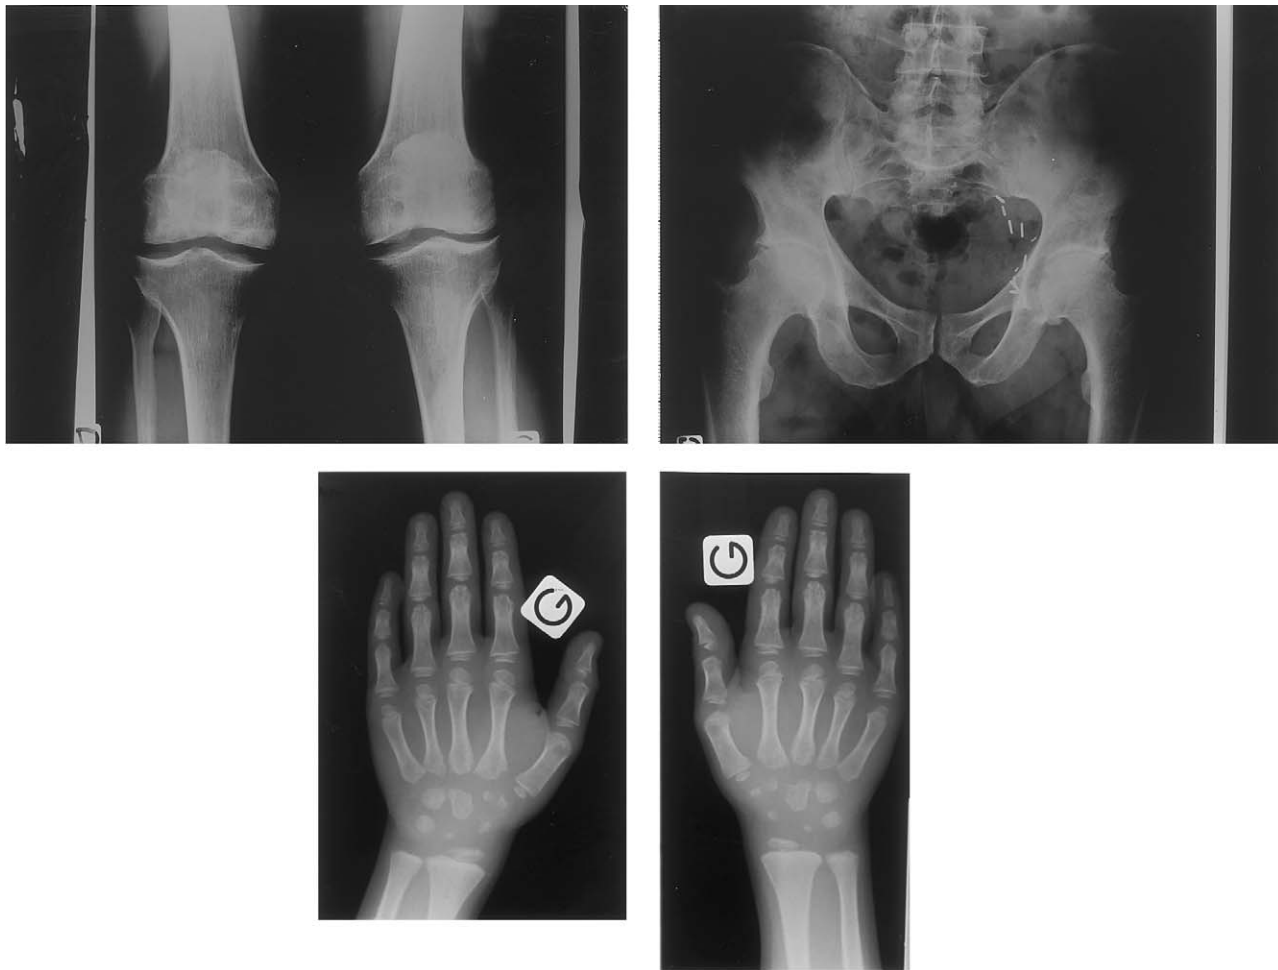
Roentgenograms of the knees (A), pelvis (B), and hands (C) of subject IV-1
